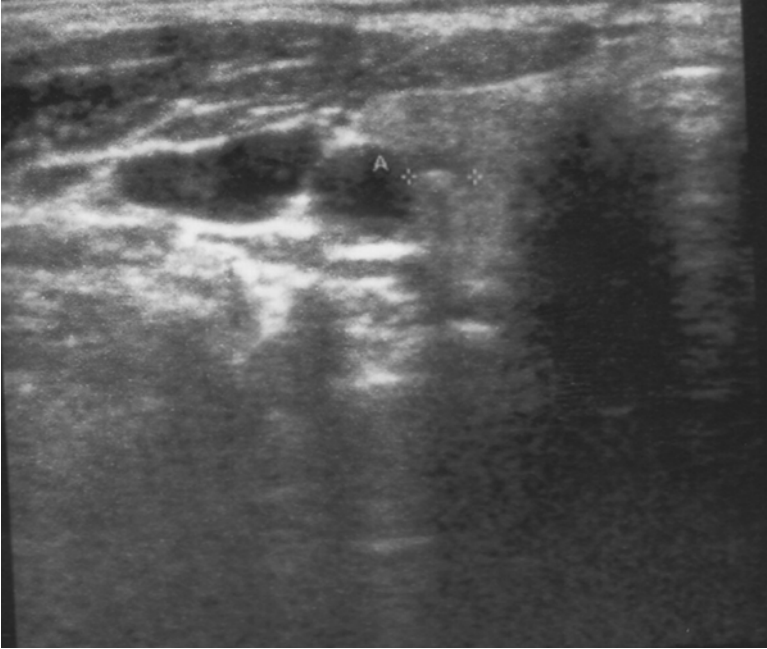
Ultrasound of the right thyroid lobe showing a small calcified nodule 4.8 mm in size
